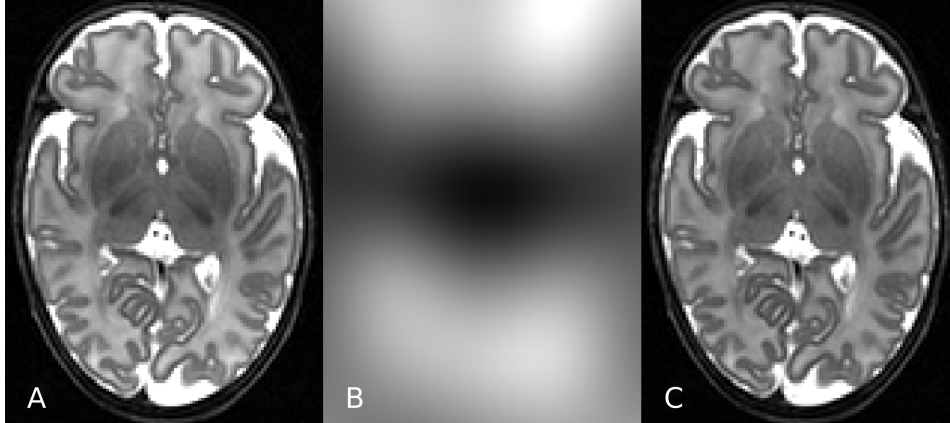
MRI intensity inhomogeneity exhibited on a neonatal T2 MR image acquired at 37 weeks PMA (A). Images (B) and (C) present the estimated bias field and bias-corrected image, respectively, using the N4 bias field correction (Tustison et al., 2010).
